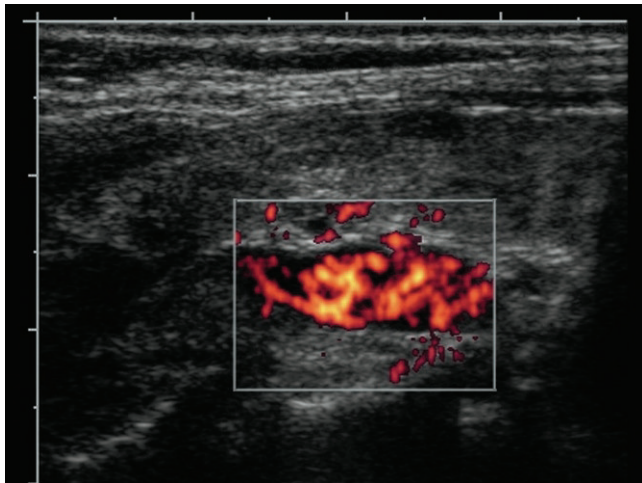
In another patient there is increased power Doppler in this adenoma.
